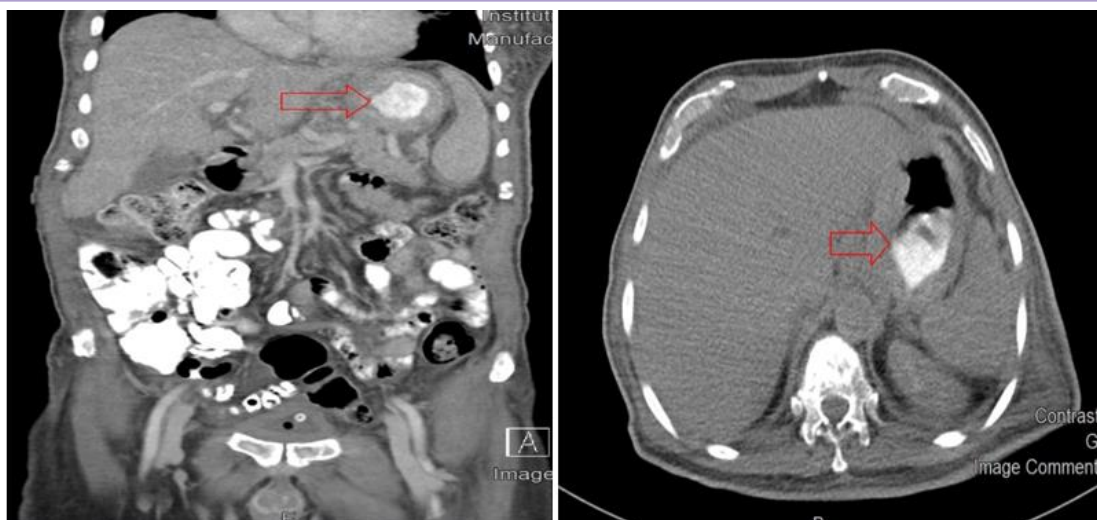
CT abdomen showing irregular mass at the gastric cardia
